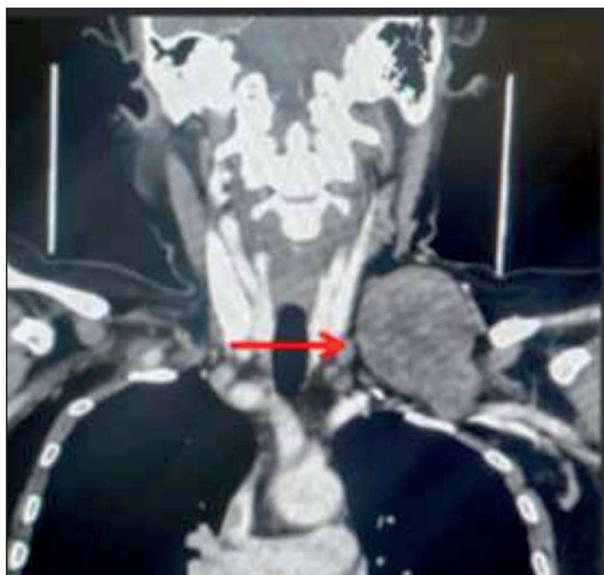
Coronal section of a contrast enhanced CT thorax with red arrow marking the tumour
